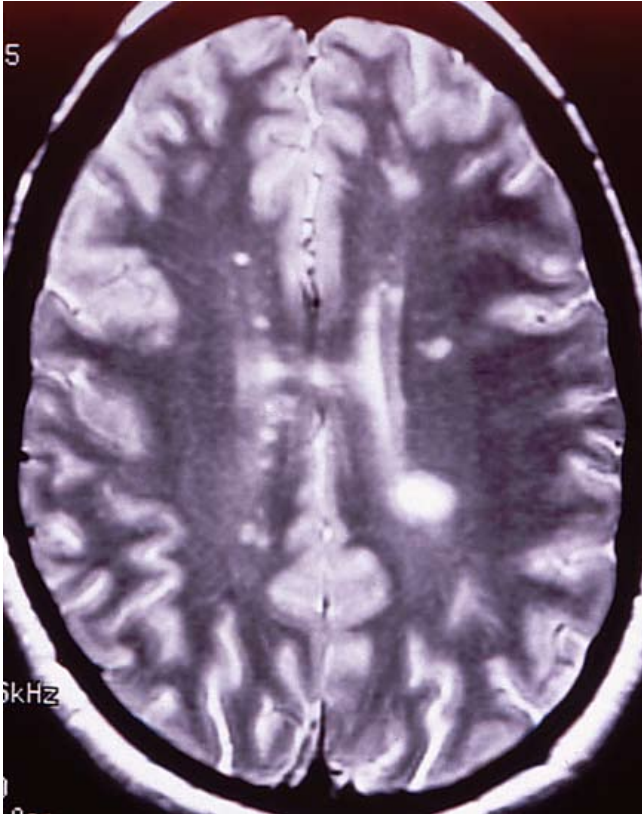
MRI in a case of multiple sclerosis
